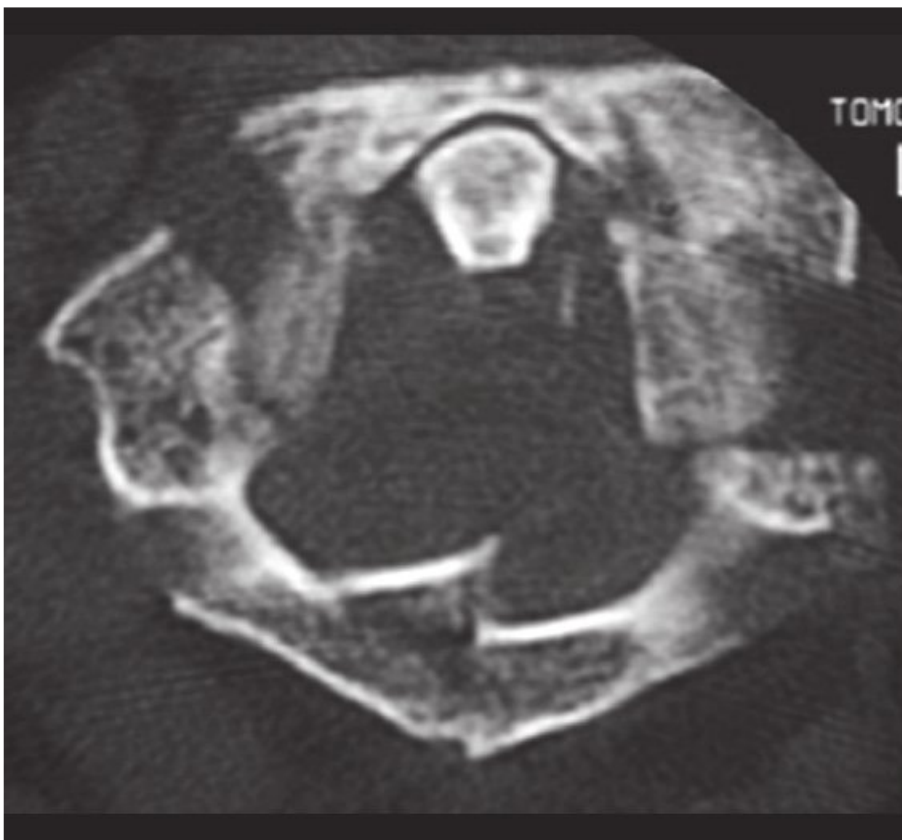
Axial computed tomographic image of a Jefferson fracture. (From Imhof H, ed. *Spinal Imaging [Direct Diagnosis in Radiology]*. Stuttgart, Germany: Georg Thieme Verlag; 2008: Fig. 2.16b. Reproduced with permission.)
